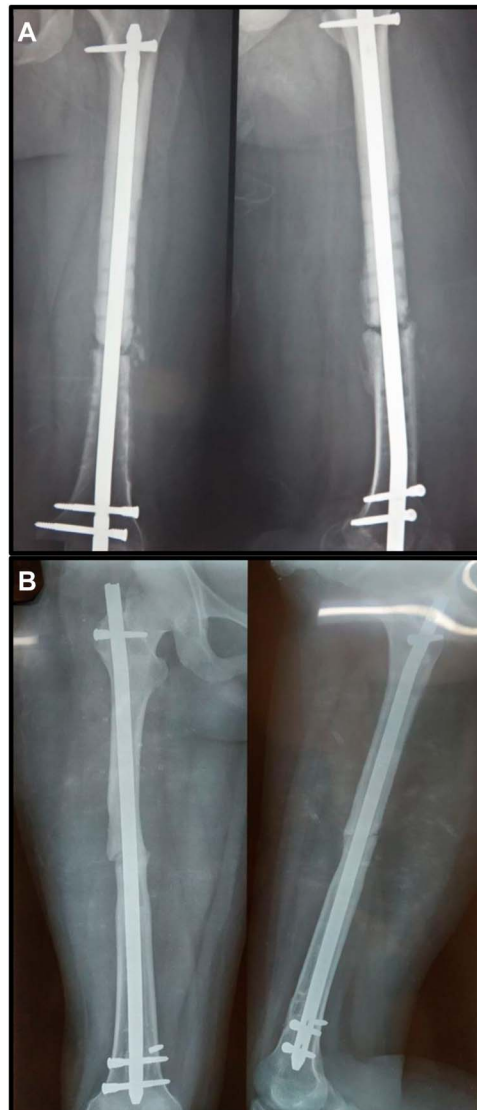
Scoring of postoperative IMN gapping. This figure displays examples of the dichotomized methodology used to determine fracture distraction: Image “A” comprised 2 radiographs depicting a “distracted” fracture (width between proximal and distal bone is more than half of the width of interlocking screws) in both the anteroposterior (top right) and lateral (top left) views, and image “B” are 2 radiographs depicting a “no distraction” fracture (width between proximal and distal bone is less than half of the width of interlocking screws) in both the anteroposterior (bottom left) and lateral views (bottom right).
